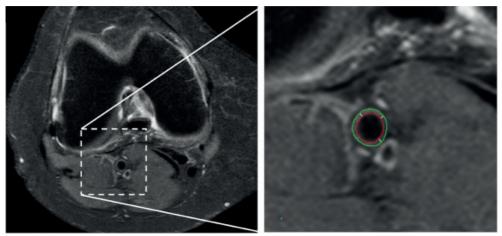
Axial MR image of the knee used for assessment of the popliteal vessel wall thickness. The right image shows an enlargement of the popliteal artery area. The green line indicates the outer vessel wall boundary, the red line indicates the lumen. At each analysed slice, the vessel wall thickness is calculated as the average distance between the outer and inner vessel boundary at four points (white lines).
